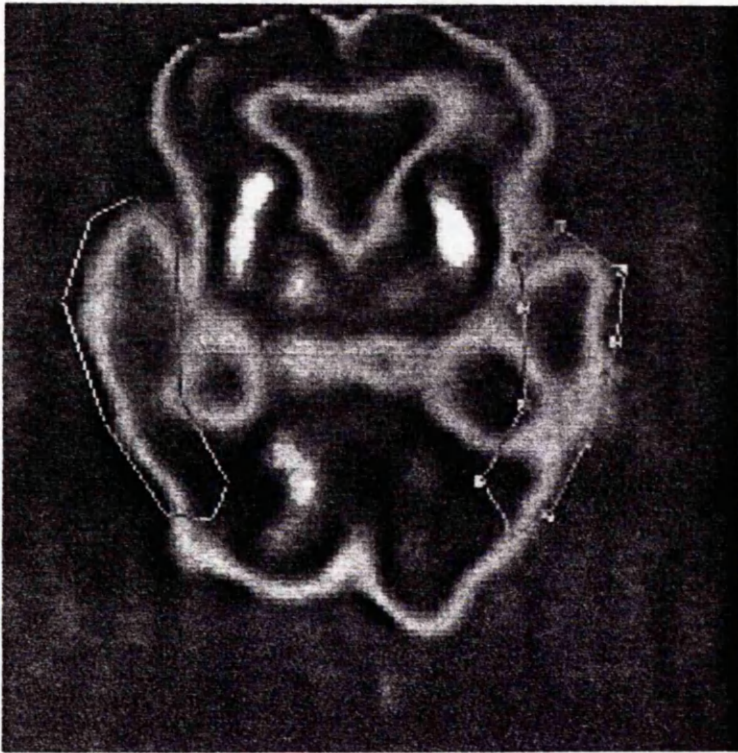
SPECT image of a DAT subject.
